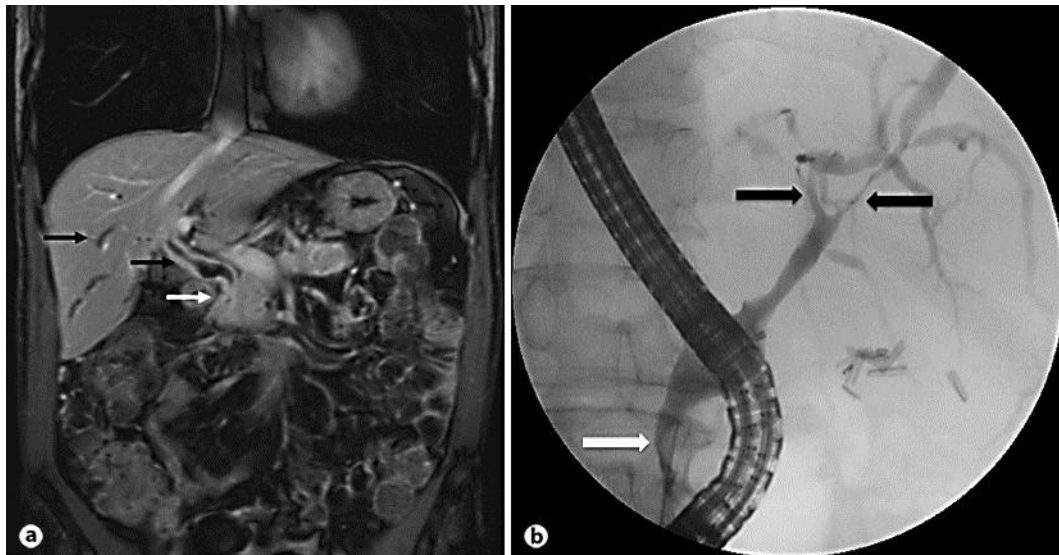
a Initial contrast-enhanced T1-weighted image showing swelling of the processus uncinatus (white arrow) and conspicuous cholestasis (black arrows). b Likewise, initial ERCP revealed a significant stenosis of the distal DHC induced by pancreatic head swelling (white arrow) and biliar strictures of the main hepatic bile ducts (black arrows).
